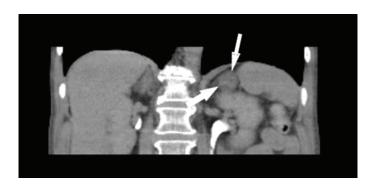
Axial section of the CT Scan showing the left adrenal myelolipoma
